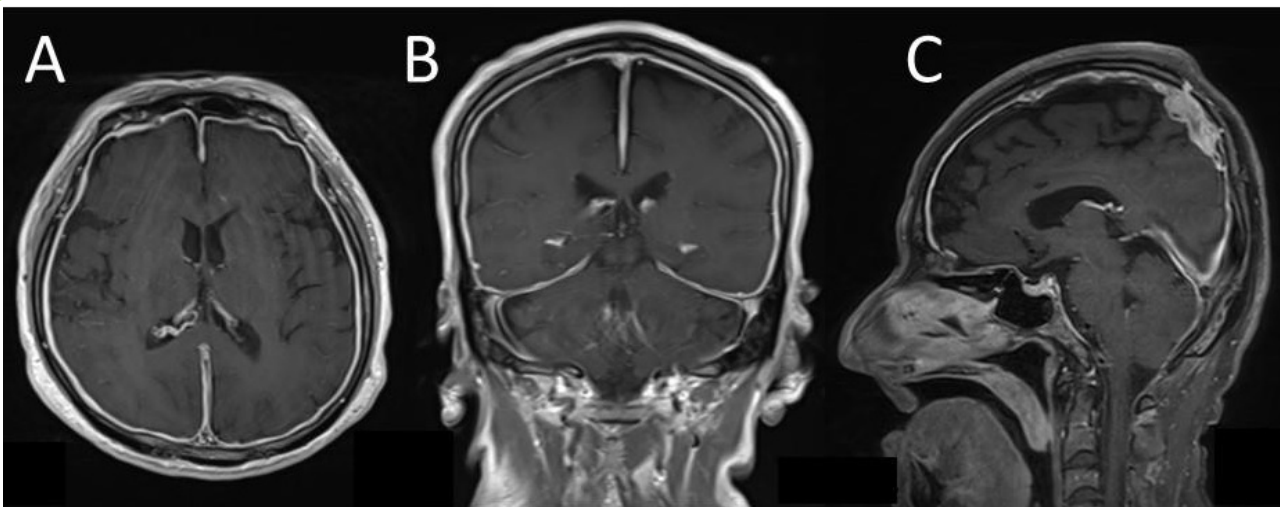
Gadolinium-enhanced T1-weighted images demonstrating (A)(B) evenly enhanced diffuse hypertrophic dura mater and (c) a mass at the lateral midline.
